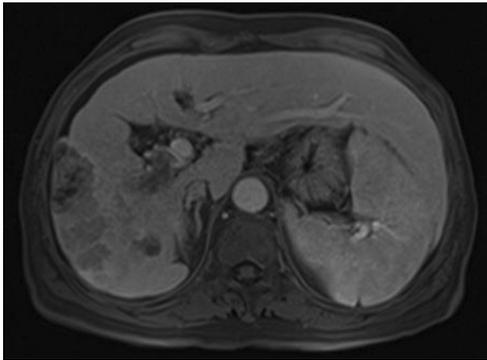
Preoperative MRI image of the abdomen showing a large irregular conglomerated mass with partial necrotic cystic changes in the inferior segment of the right lobe of the liver. A right posterior portal vein thrombus was detected through the first order branch.
